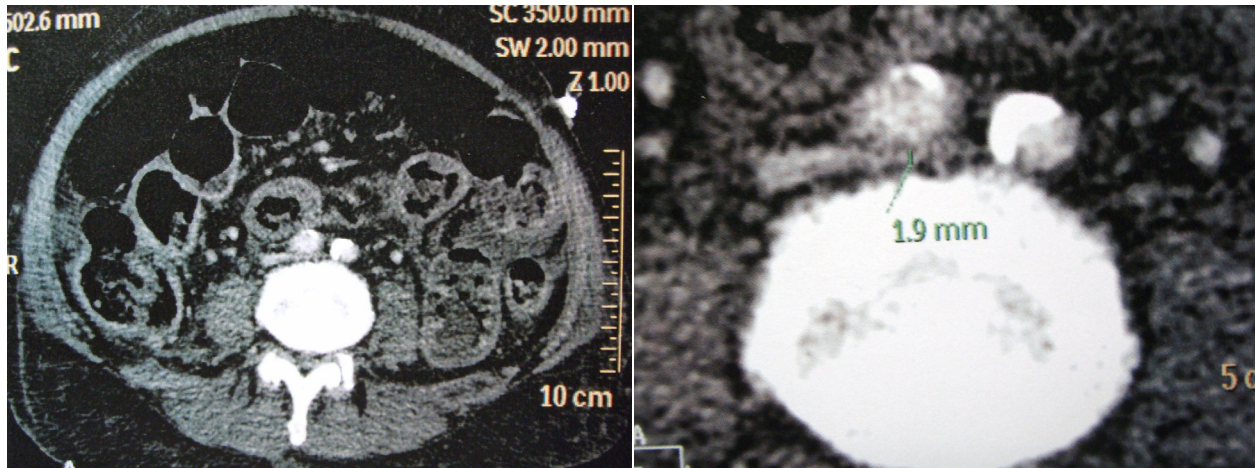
Axial portovenous phase of abdominal CT reveals compression of left common iliac vein (left CIV) by right common iliac artery (right CIA)
